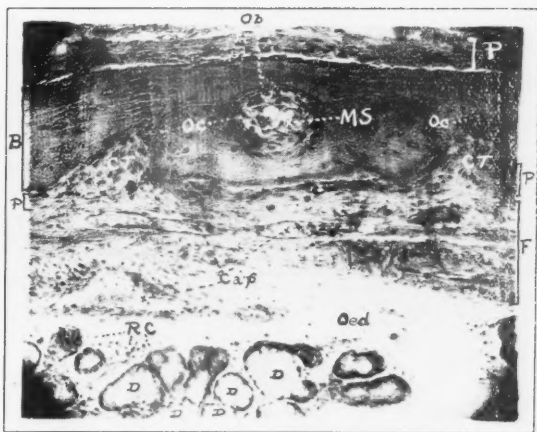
Turbinate. Simultaneous osteoclastic and osteoblastic activity, with fibrosis of bone ($\times 300$). P—Periosteum (extremely thickened). Ob—Osteoblasts. B—Bone. MS—Medullary space. Oc—Osteoclastic activity from young connective tissue. CT—Connective tissue, following osteoclasts. Cap—Blood capillaries. Oed—Edematous tunica propria. RC—Round cell infiltration about dilated glands. D—Dilated glands. F—Fibrosis of tunica propria.
